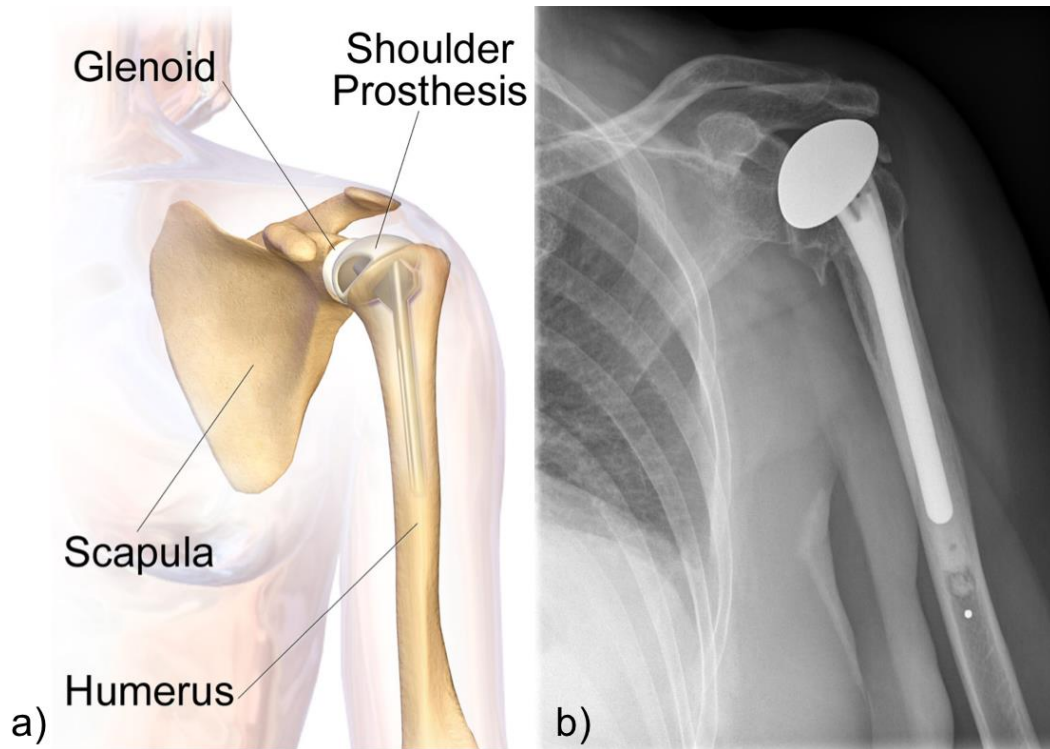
(a) Anatomic total shoulder replacement and (b) its corresponding x-ray (note the polyethylene glenoid component is radiolucent and does not show up on x-rays). Figures under license to use and modify.
